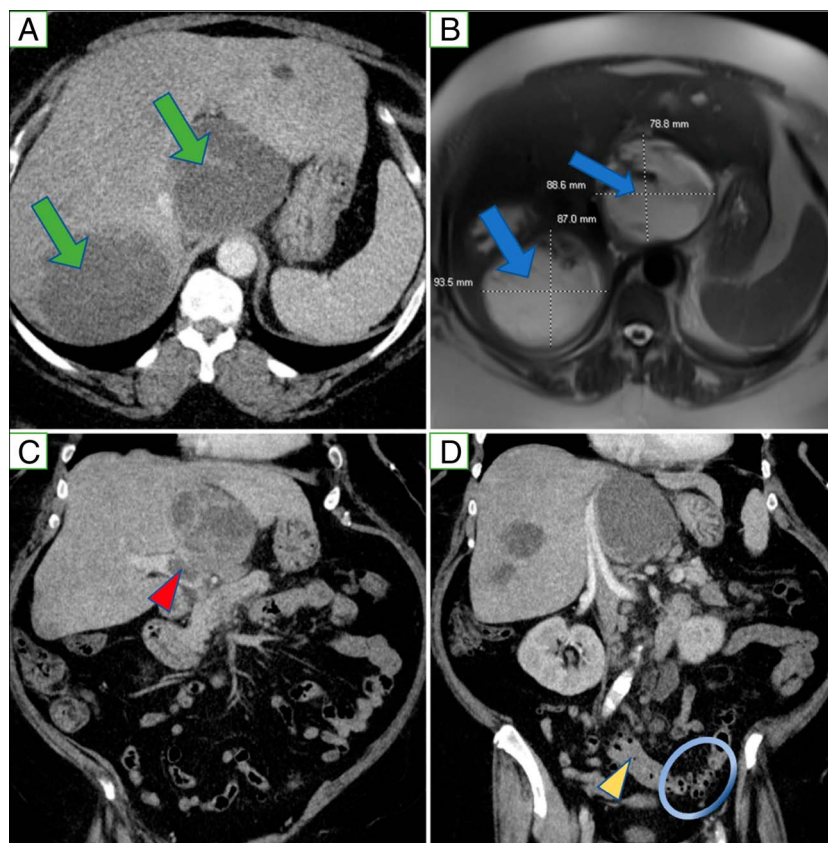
(A) Abdominal and pelvic CT with IV contrast showing 2 large hepatic abscesses (green arrows) up to 9 cm in size. (B) Abdominal MRI T2 showing the 2 large hepatic abscesses (blue arrows). (C) Abdominal and pelvic CT with IV contrast showing subocclusive thrombus in the portal vein (red arrow head). (D) Abdominal and pelvic CT with IV contrast showing thickening of the sigmoid colon wall (yellow arrow head) and colonic diverticula (encircled). CT, computed tomography; IV, intravenous; MRI, magnetic resonance imaging.
